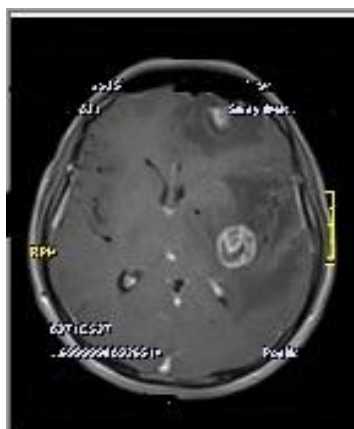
Cranial lesion due to Toxoplasmosis in coronal MR image
